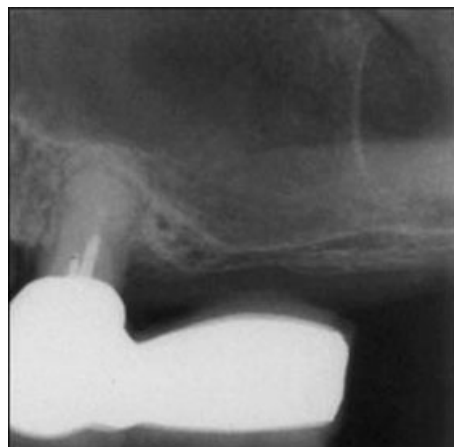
Radiograph showing a large pneumatized maxillary sinus, where a two-stage sinus floor elevation with a delayed implant insertion has to be used.
